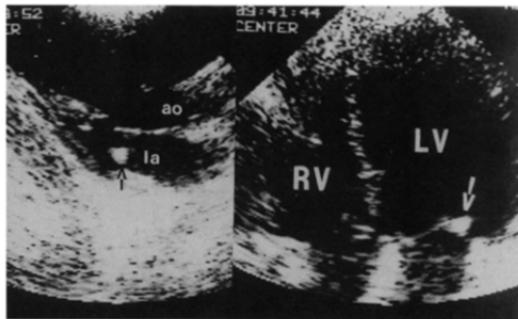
Patient 5. Parasternal long-axis view (left panel) and apical four-chamber view (right panel) in a 28-year old woman. A vegetation-like mobile and echogenic mass is attached to the posterior mitral leaflet (arrows). ao = aorta; la = left atrium; other abbreviations as in Figures 1 and 2.
